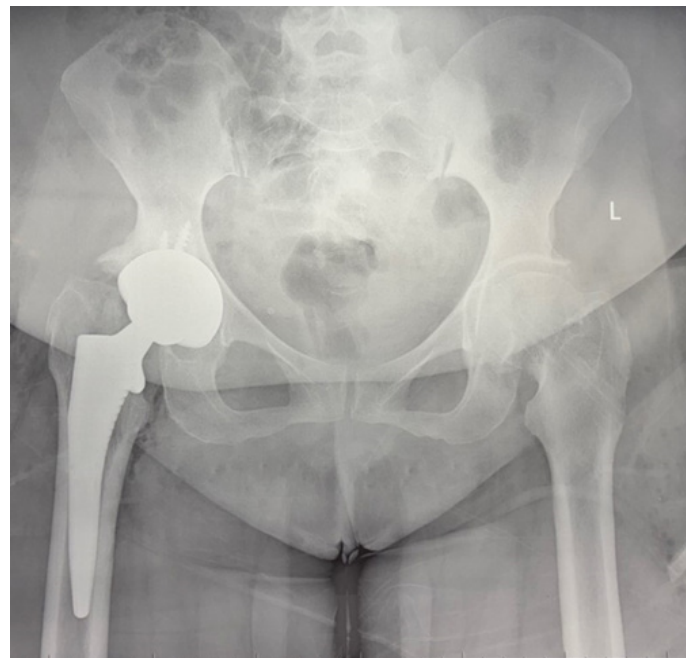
Post op AP Pelvis Radiograph: Right Total Hip Arthroplasty and Left Hip Post Removal of Knowles Pin
